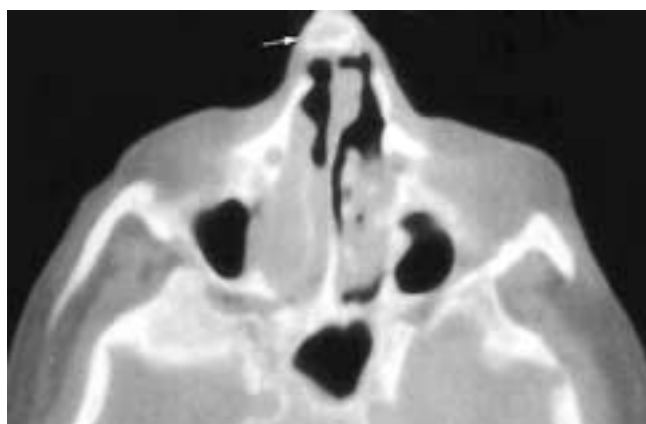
Axial CT scan shows a rib (*arrow*) used in a nasal reconstruction. There is unrelated inflammatory disease in the nasal cavities.
